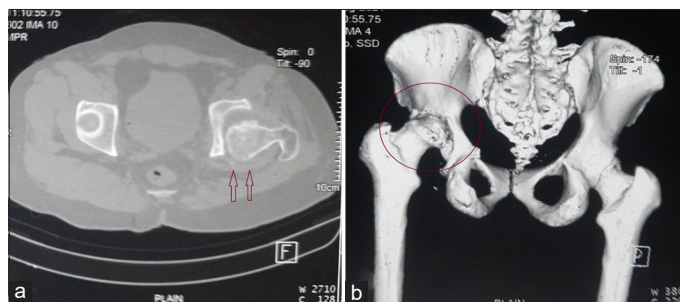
Computed tomography image showing (a) deficient posterior acetabular wall; (b) posterior acetabular wall deficiency with flattened femoral head
